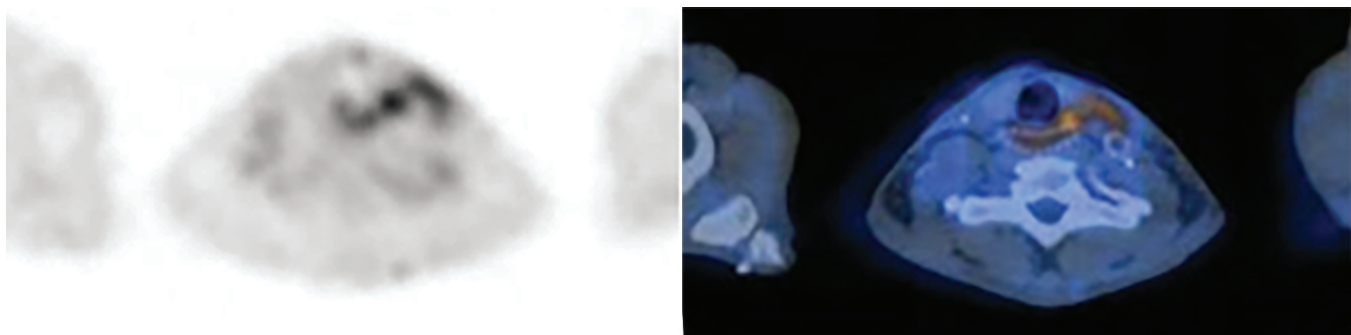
Positron emission tomography (PET) CT showing the active infection at the site of the LF carotid graft anastomosis
